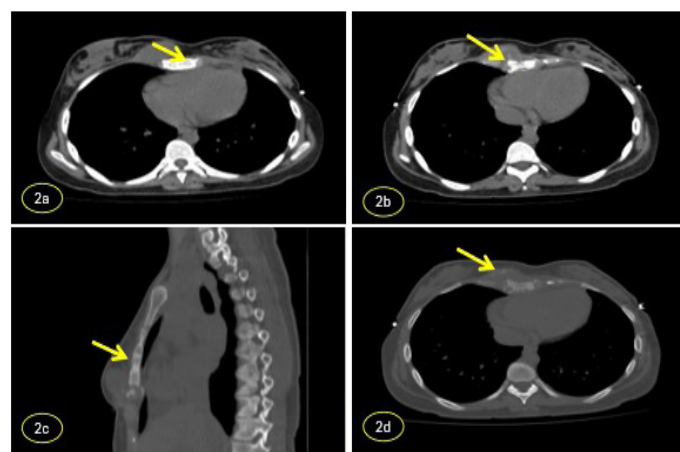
Non-contrast CT chest in soft tissue (2a, 2b) and bone window settings (2c, 2d), axial and sagittal views. The scans demonstrate a well-defined hypodense collection arising from the sternum, extending into the right parasternal soft tissues, consistent with a cold abscess. Associated cortical destruction of the sternum with internal involucrum formation is evident, indicating underlying sternal osteomyelitis.
